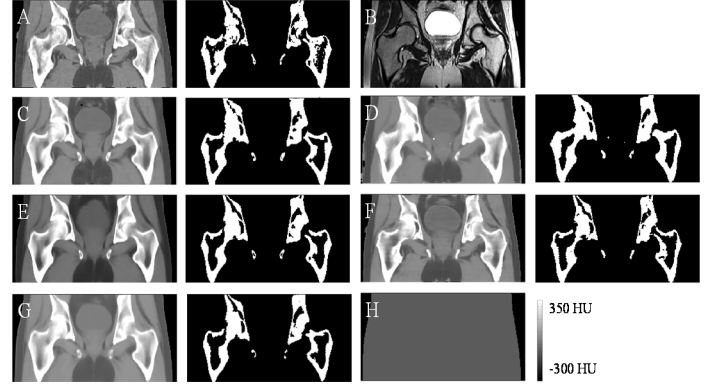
A) Reference CT, B) Target MRI, C) Pseudo-CT of A-Iter, D) A-VW, E) A-Bone, F) DL-CNN, G) A-Median and H) 2 tissue-class (Water-only).
